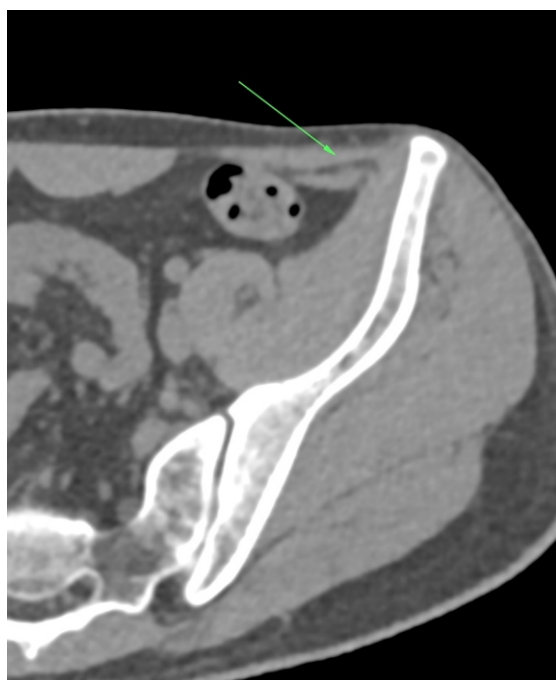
Corresponding axial CT scan matched with the axial MRI to locate the abnormal nerve on CT.
